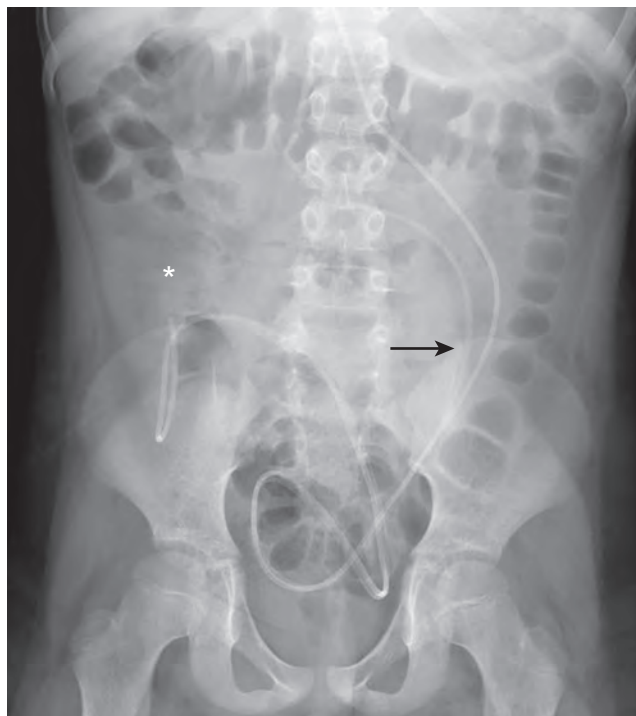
Clearance of large bowel contents with antegrade enemas. Abdominal radiograph taken 12 hours after washout, demonstrating absent fecal material except for early accumulation in the cecum and ascending colon (asterisk). Note presence of a ventriculoperitoneal shunt (arrow).
